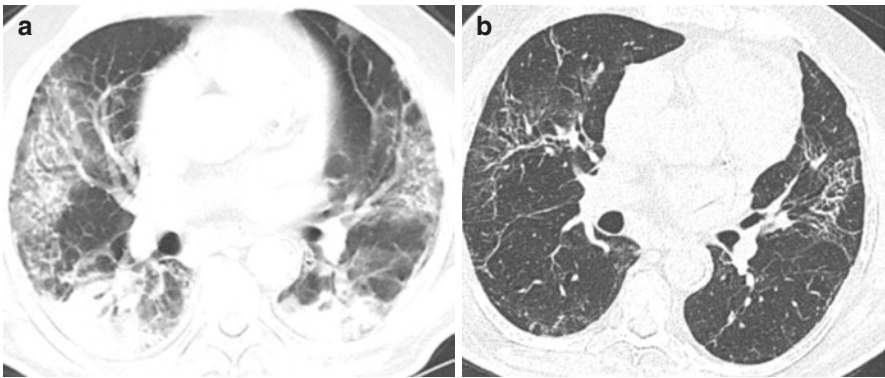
CT features at baseline (a) and after 1 year (b) in a 73-year-old male who developed severe COVID-19 pneumonia. (a) Baseline CT showing bilateral consolidation and ground-glass opacities (GGOs) with peripheral and peribronchovascular distribution. (b) One-year CT follow-up demonstrating GGOs and consolidations replaced by areas of fibrotic-like changes showing reticular opacities, interlobular septal thickening with associated bronchial dilation/distortion
